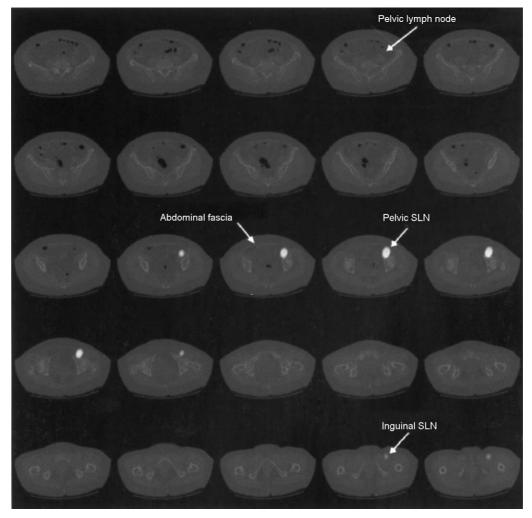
Fusion image of SPECT and pelvic CT-scans demonstrating an inguinal and a pelvic SLN as well as a radioactively labelled pelvic node. The dynamic images of the same patient are shown in Fig. 2.
